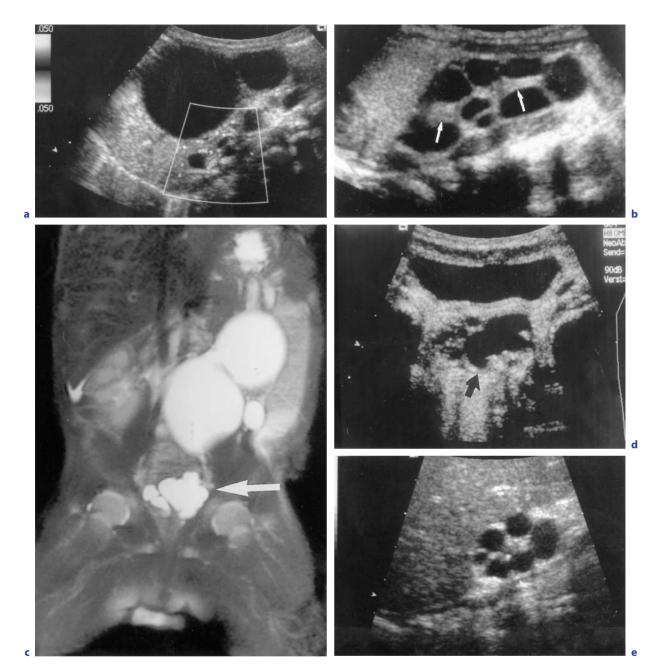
e. MCDK: a US images showing longitudinal section of multiple, non-corresponding cystic masses and some echogenic-dysplastic, non-differentiated parenchyma (*arrow*). b CDS demonstrates vasculature in the echogenic dysplastic parenchymal part of this MCDK. c 3D reconstructed MRI image of a MCDK with associated cystic dysplastic malformation of the ipsilateral seminal vesicle and rete testis, also demonstrated by US on a transversal section behind the bladder (*arrow*) (d). e US of spontaneous regression/involution of an already relatively small MCDK (*arrow*) in a longitudinal section
